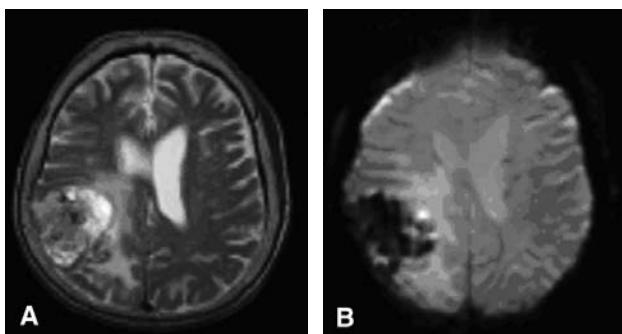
(A) SE T2-weighted images (TR/TE/flip angle = 3800 ms/102 ms/90°) from a 3-T scanner for a patient with a tumor in the right parietal lobe. (B) GE T 2^* -weighted images (TR/TE/flip angle = 4000 ms/30 ms/90°) of the same patient. The main difference between the two images is that there is a large signal dropout on the T 2^* sequence in the area of the tumor. This is caused by small local field inhomogeneities in the tumor caused by microcalcifications and small hemorrhages. The SE sequence is less sensitive to these small local field inhomogeneities. Therefore, the tumor exhibits signal intensity close to that of the normal brain. However, the T 2^* sequence is very sensitive to these local field inhomogeneities, which causes rapid spin-spin relaxation and a prominent dropout in signal.
